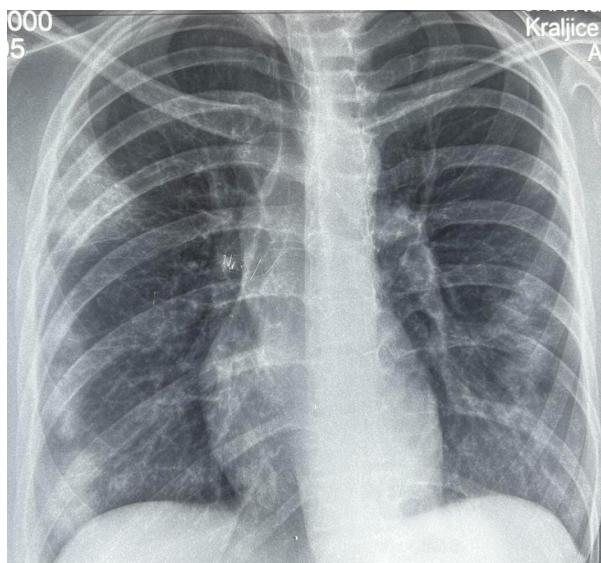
The first X-ray of the lungs
